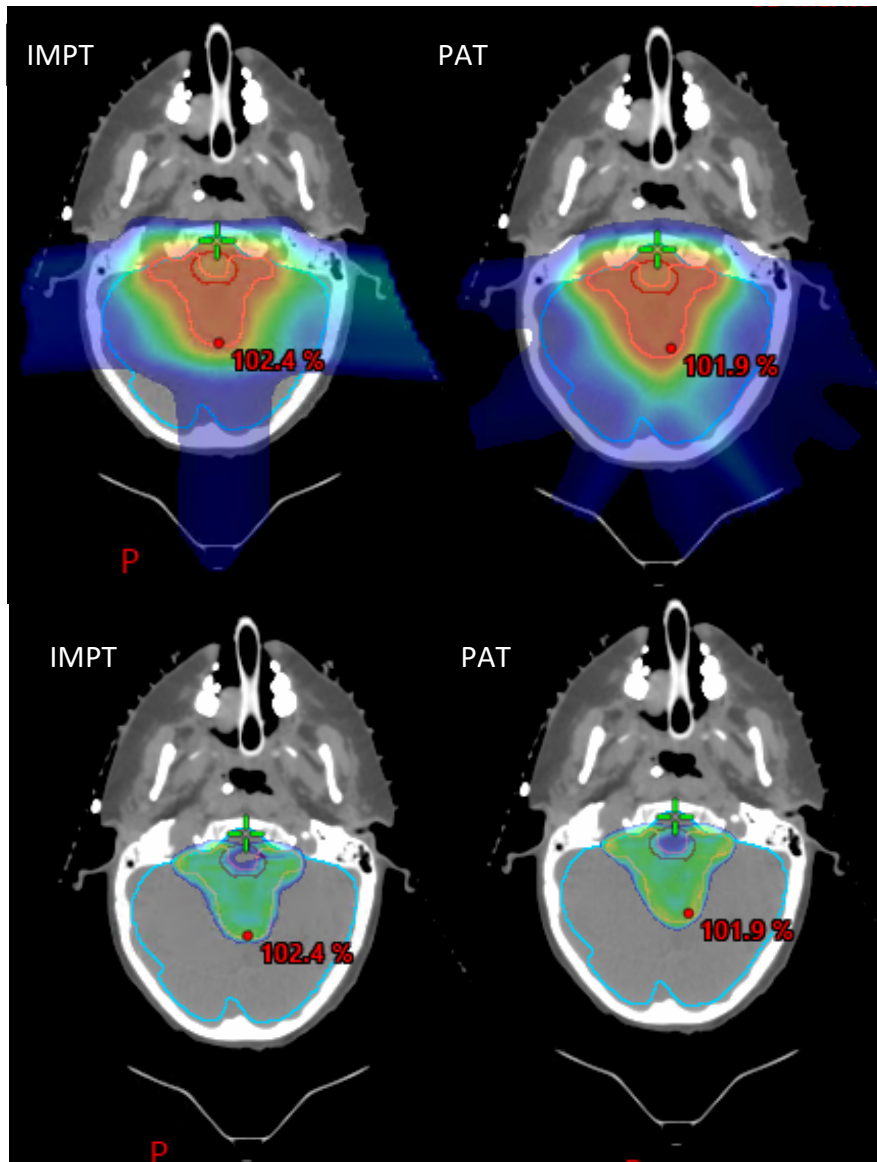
3: A CT slice of the dose distribution for a IMPT and a PAT plan. The two lowest slices show the dose distribution from 95% of the prescribed dose. The blue line represents the brain, the pink (sometimes yellow) line is the tumor and the red line represent the brainstem.
